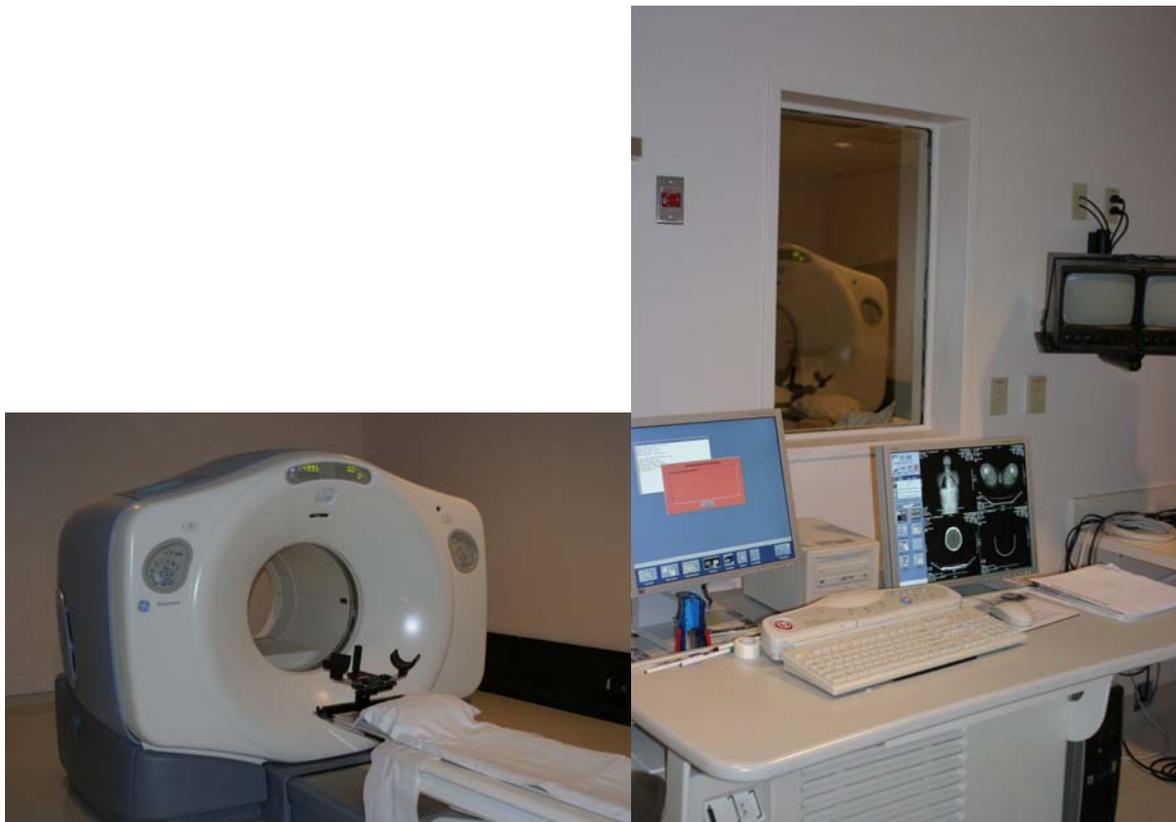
Different views of a modern PET/CT suite
